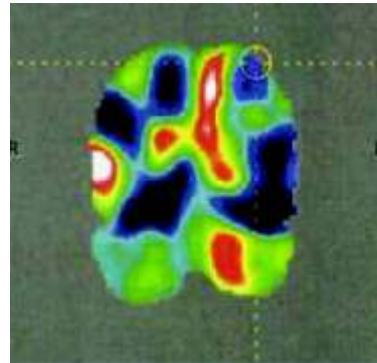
PET-CT scan after Autologous BMMNCs showing improved metabolism in the regions of anterior, middle and posterior cingulate gyrus, amygdala, hippocampus and parahippocampus
